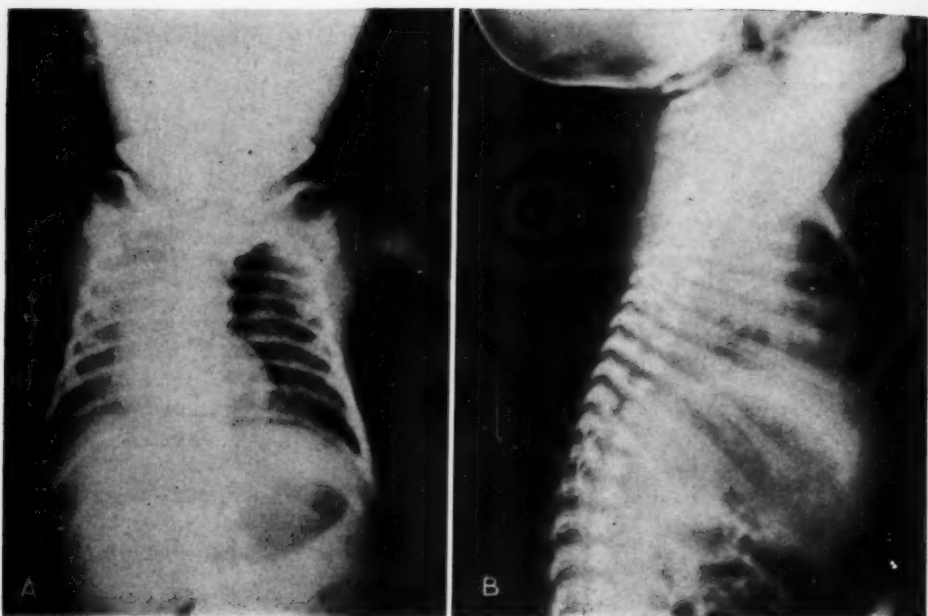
Case 2: A. Roentgenogram made 72 hours after birth, showing air in the anterior mediastinum. B. The lateral negative shows air in the superior and anterior mediastinum with slight posterior displacement of the heart.
